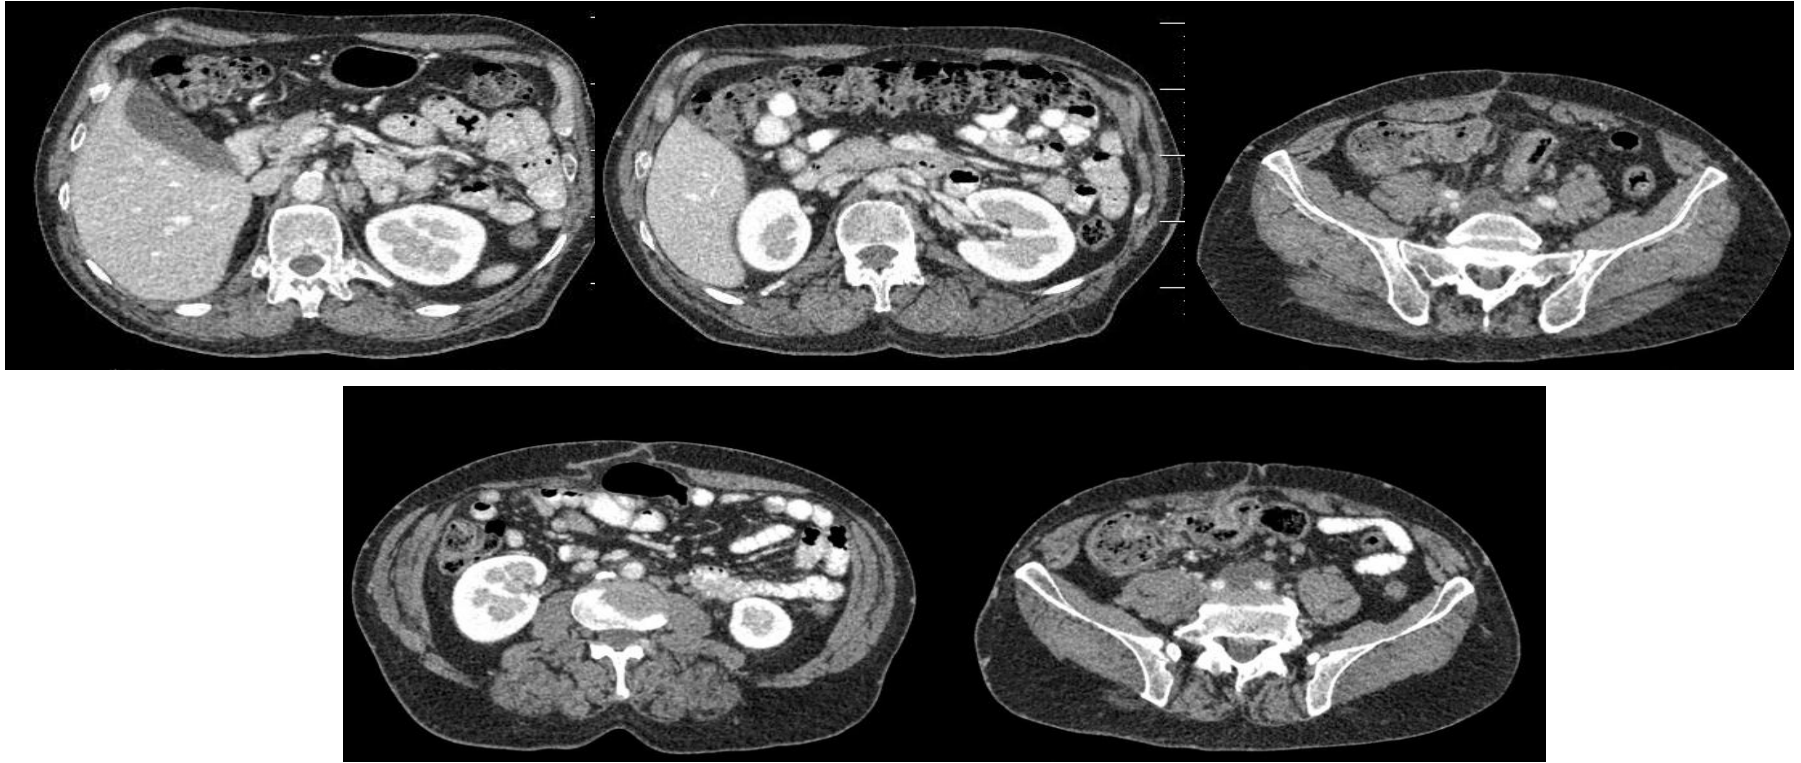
Same patient as in figure 1. CT of the abdomen shows irregularly distended inferior vena cava, with occupation of its lumen by a solid heterogeneous nodule enhancing soft-tissue mass that extends to iliac veins with signs of necrosis. A solid component is also seen in contact with the right wall of the IVC. These findings are suggestive of leiomyosarcoma with combined extra and intraluminal growth.
